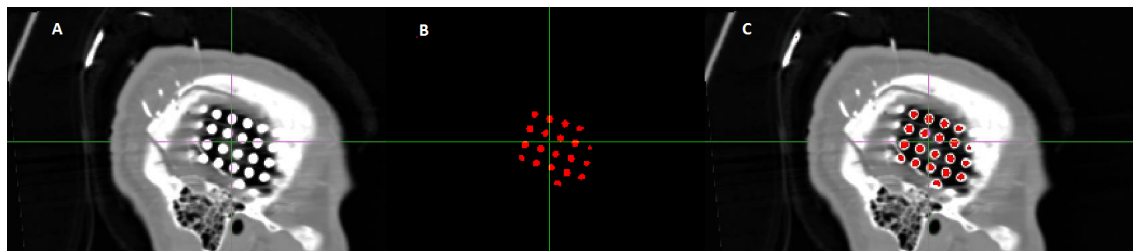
A - CT image with whole head; B - CT mask, after the thresholding and binarization C - Fusion of CT dataset with CT mask.
